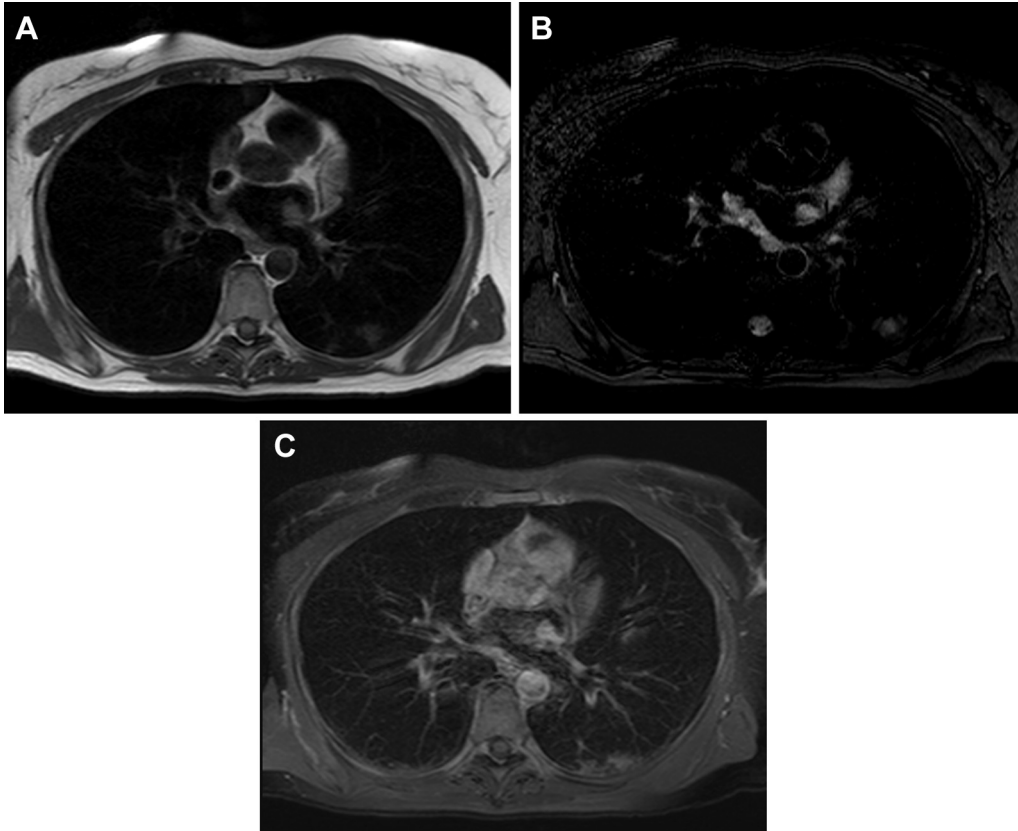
(A-C) Cardiac magnetic resonance images demonstrate left atrial mass along the left superolateral wall, adjacent to the atrial appendage base, measuring 1.3×1.2 cm, of intermediate T1 signal intensity (A), mildly hyperintense T2 signal intensity (B), and with avid enhancement on postcontrast fat-suppressed T1-weighted images obtained after the intravenous administration of 13 mL of gadolinium-based contrast (MultiHance; C).
